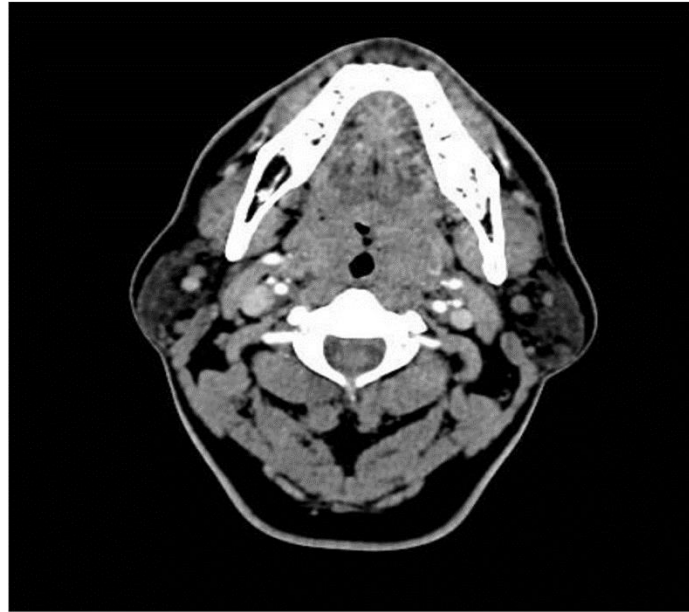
Contrast-enhanced axial CT scan of the neck showing diffuse enlargement and heterogeneous enhancement of the tongue associated with bilateral cervical lymphadenopathy.
